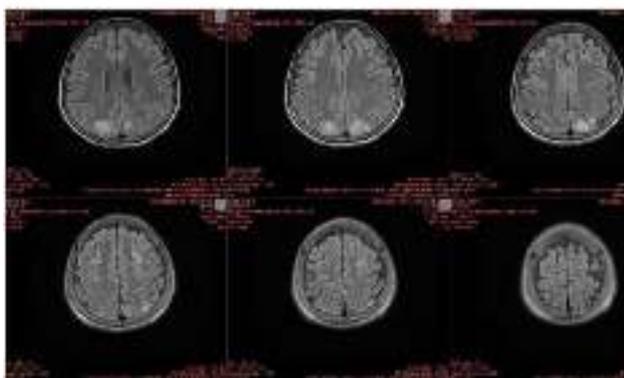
Kranial MR imaging of the patient
